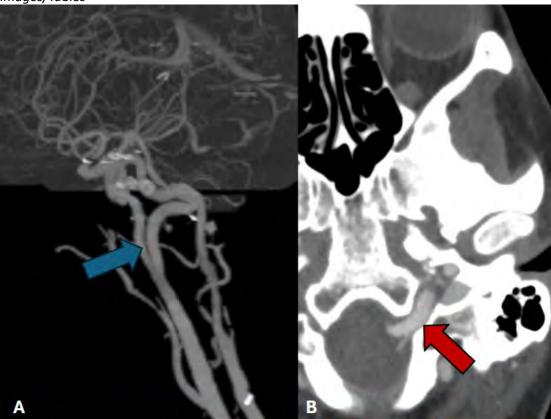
Sagittal 3D volume-rendered image (A) and axial maximal intensity projection image (B) of the patient's CT angiogram of the head demonstrate variant persistent left hypoglossal artery, with connection between the distal cervical internal carotid artery and the basilar artery (blue arrow). There is also expansion of the left hypoglossal canal (red arrow).
